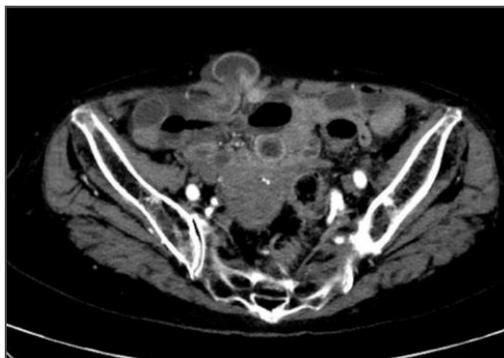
Preoperative CT. CT investigation revealed protrusion of the small intestine from the right rectus abdominis muscle.
